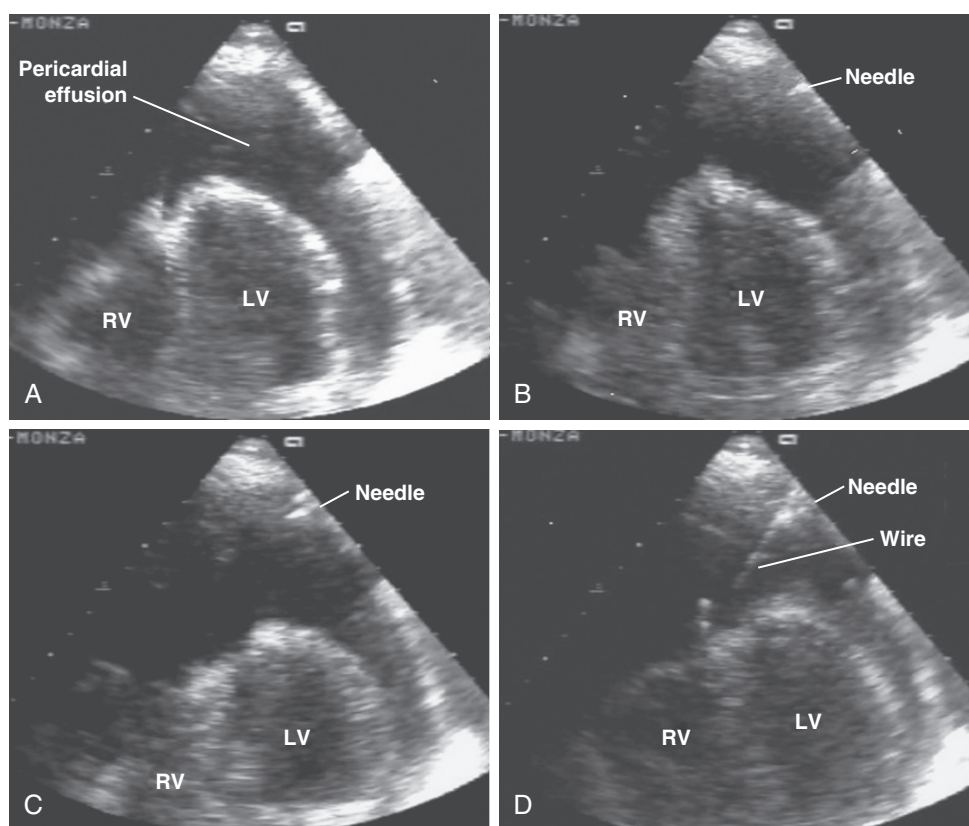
■ Two-dimensional echocardiographic image (apical four-chamber view) during needle introduction through tissues. A, Detection of pericardial effusion. B, Visualization of needle tip. C, Needle is advanced through tissues. D, Needle enters pericardial space and guidewire is introduced. LV, left ventricle; RV, right ventricle. (From Maggiolini S, Bozzano A, Russo P, et al: Echocardiography-guided pericardiocentesis with probe-mounted needle: report of 53 cases. *J Am Soc Echocardiogr* 2001;14:821-824.)
